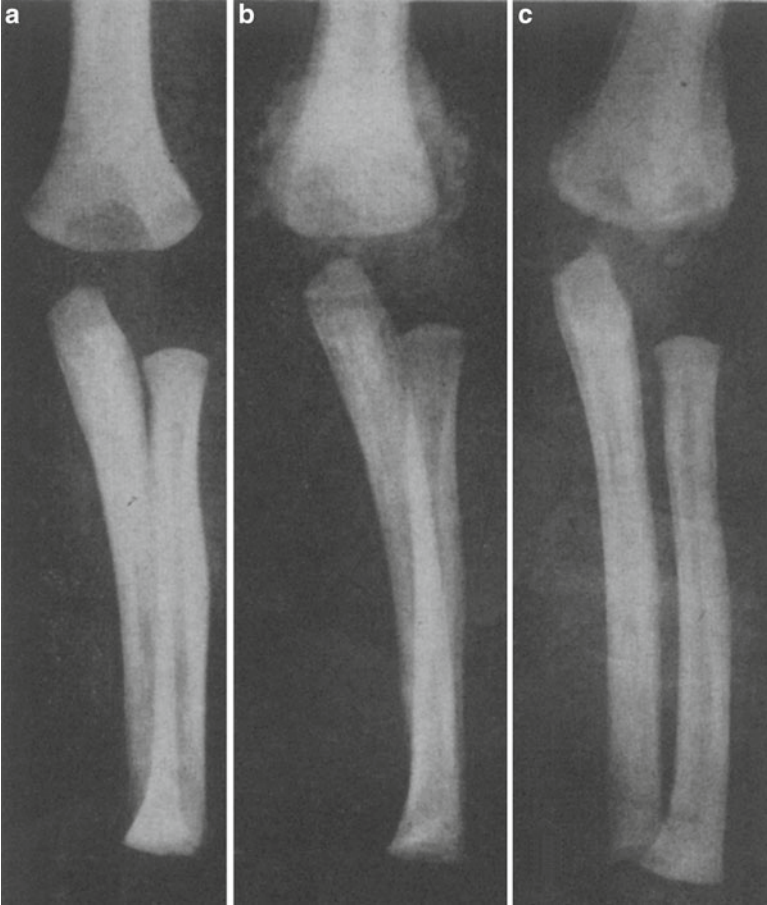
Female 7 1/2 months: *a*, Elbow injured 30 hours before, except for thickened cortex from previous healed reactions, no radiologic signs of injury; *b*, Fifteen days after injury, irregular productive reaction, clinically normal joint; *c*, Three weeks after *b*, organization and healing progressing nicely. (By permission of *Amer J Roentgenol.*)
